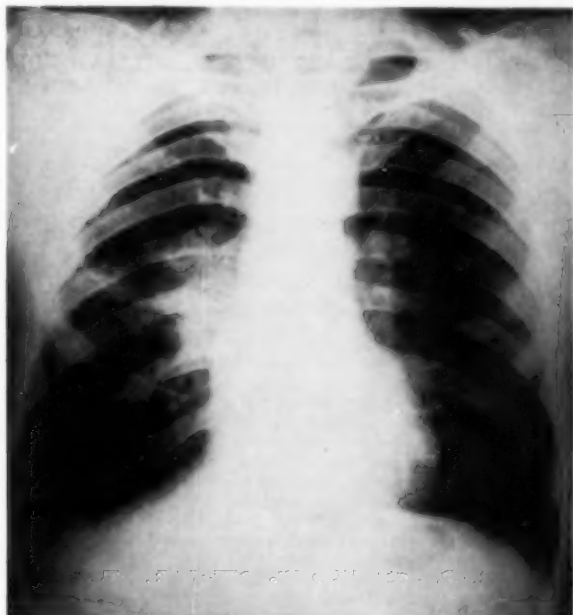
Chest roentgenogram demonstrates an infiltration in the right hilum and right upper lobe.
